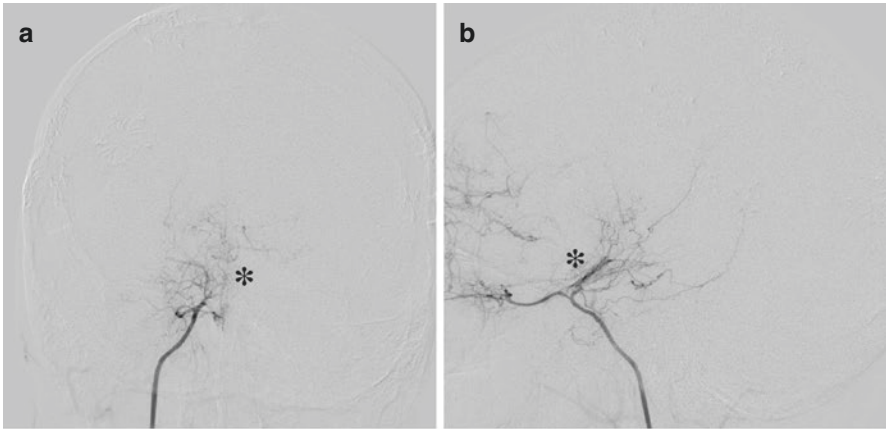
A 12-year-old patient with bilateral moyamoya disease initially underwent bilateral STA-MCA direct bypass at age 7 when she presented with weakness and speech disturbance. She subsequently presented with left-sided weakness, and choreiform arm and leg movements after 5 years of being symptom free. (a, b) Right ICA injections (AP & lateral views) showing an occluded terminal ICA with moyamoya collateralization (*asterisks*). (c, d) Right CCA injection (AP & lateral views) post right direct STA-MCA bypass showing the patent bypass graft with collateralization of the right MCA territory (*arrows*), but with an area of reduced cerebral perfusion of the posterior MCA (*area outlined*). (e, f) Left ICA injections (AP & lateral views) showing an occluded left supraclinoid ICA/ACA/MCA with moyamoya vessels (*asterisks*). (g, h) Left CCA injections (AP & lateral views) post left direct STA-MCA bypass showing extensive collateralization to the left hemisphere, and patent bypass graft (*arrows*). (i) Repeat MRI of the brain showing no new evidence of cerebral ischemia, but with areas of old bilateral watershed infarcts. (j) SPECT cerebral blood flow studies showing impaired right hemispheric perfusion with poor cerebrovascular augmentation with Diamox. (k, l) Due to the large area of posterior MCA to be revascularized, she underwent right omental-cranial transposition with intraoperative position, exposure, and final wide omental coverage of the right hemisphere. Her choreiform movements and TIA symptoms resolved within 3 months postoperatively. (m, n) Postoperative angiogram with celiac trunk injection at 6 months showing the patent pedicle of the omental flap traveling through the upper abdomen, chest wall, and neck (*block arrows*), with perfusion to a large area of the right hemisphere. (o) Angiogram at 6 months, celiac trunk injection, lateral projection through the head showing the area of revascularization by the omental graft in keeping with the area of deficient cerebral perfusion marked in (c) block arrow. (p) Technetium 99 scan at 6 months postoperative showed areas of fixed perfusion defect in keeping with old infarcts. However, the baseline perfusion was improved showing bilateral symmetrical perfusion, with Diamox augmentation. She remained symptom free at 3 years follow-up after right omental-cranial transposition
